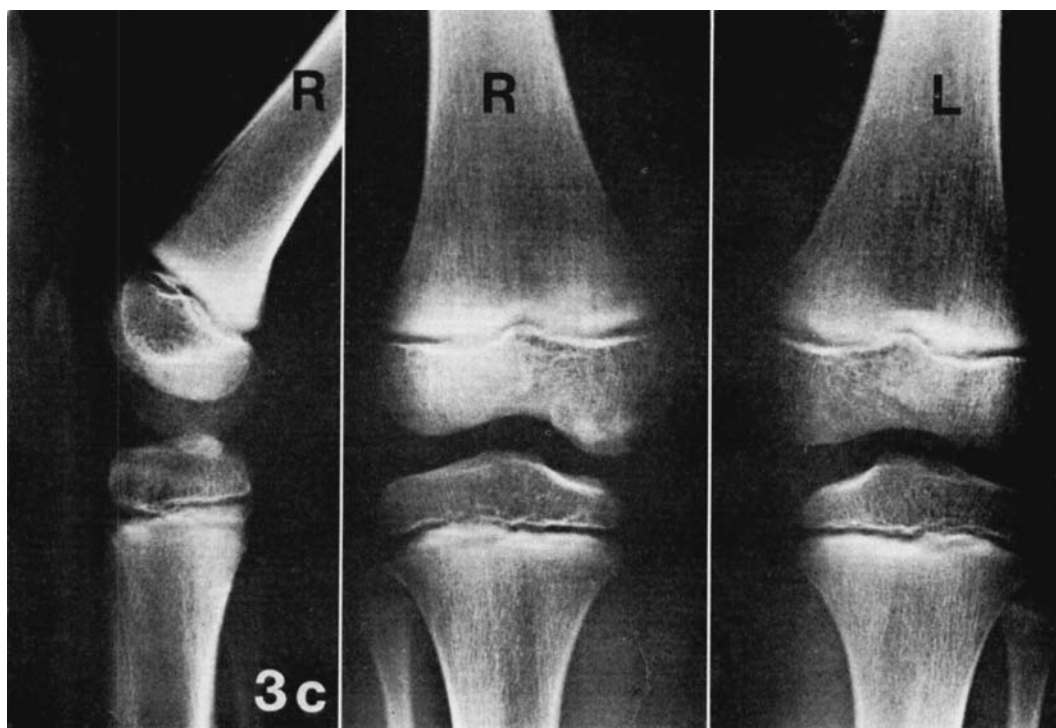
Case 3. a) X-rays of the knee joints of a boy at the age of 5 showing an enlargement of the right medial femoral condyle. b) X-rays of the ankle and foot of the same patient showing multiple centres of ossification around the talus, navicular and first cuneiform. c) X-rays at the age of 8 show some spontaneous improvement of the knee affection.
